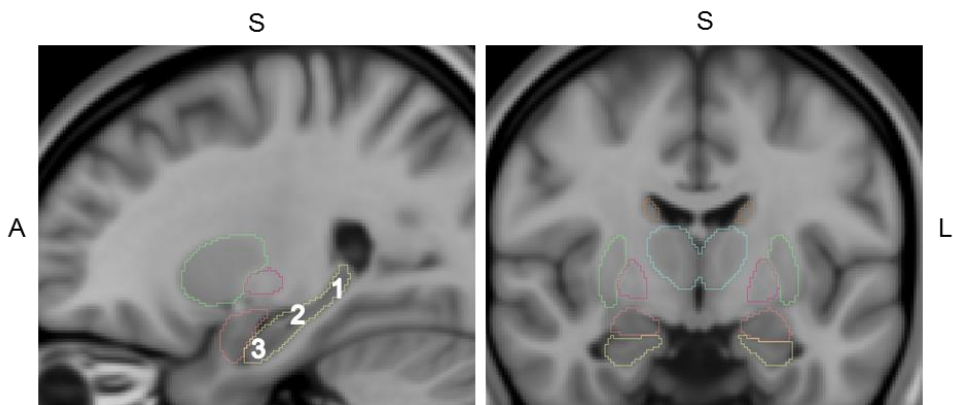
Sagittal and axial slice from the MNI152 standard-space T1-weighted template. 1: hippocampal tail; 2: hippocampal body; 3: hippocampal head; red: amygdala; green: putamen; cyan: thalamus; brown: caudate nucleus; magenta: globus pallidus. The MNI152 template brain [2] is used and structures from the Harvard-Oxford probabilistic atlas from FSL [1] are shown.
